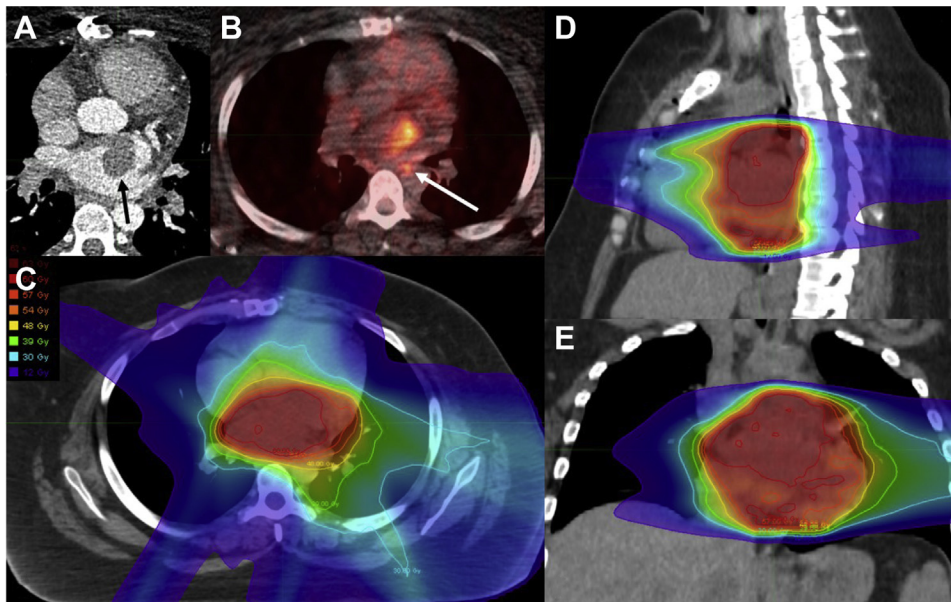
Cardiac computed tomography with contrast showing evidence of recurrence after R1 surgical resection and completion of x6 total cycles of systemic therapy (black arrow) (A). Positron emission tomography/computed tomography showing recurrent left atrial mass and posterior adjacent hypermetabolic lymph node (white arrow) (B). Radiation treatment planning images in the axial (C), sagittal (D), and coronal (E) slices.
